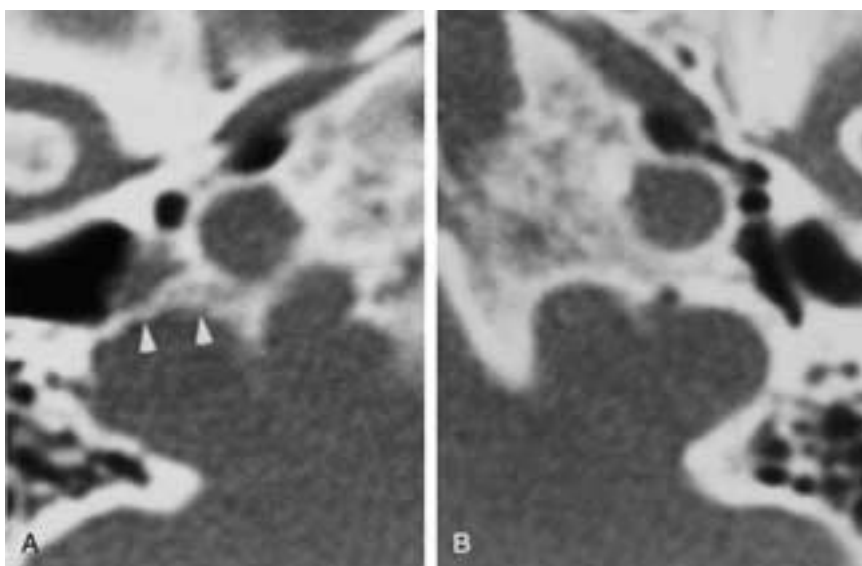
Small glomus jugulare tumor. A and B, Axial CT. Fisch type C1 tumor similar to the glomus tympanicum tumor in otoscopic appearance. Cortical demineralization of the jugular plate (arrowheads) on CT, however, indicates involvement of the jugular bulb (A). Compare with the normal contralateral side (B). Angiography is indicated, with possible preoperative embolization.
